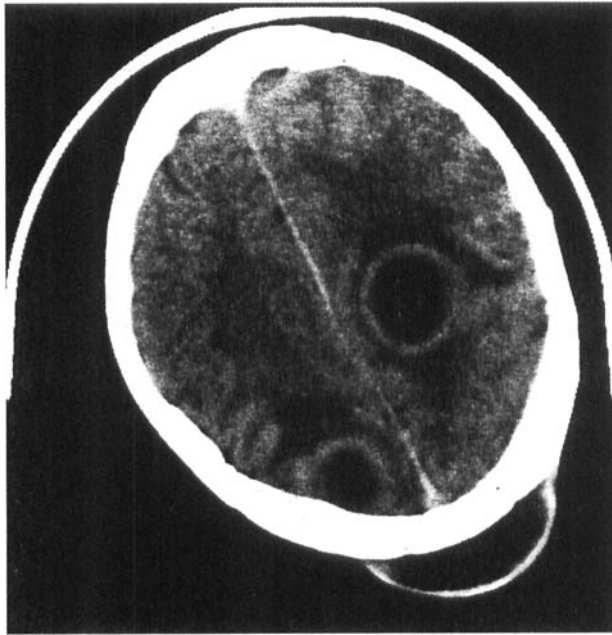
Computerized tomography (CT) scan of head showing two lesions consistent with brain abscess. Ring enhancement (by contrast material) and surrounding edema. From: Finegold SM, Baron EH, Wexler HM. A clinical guide to anaerobic infections. Belmont, California: Star Publishing; 1992. By permission.
